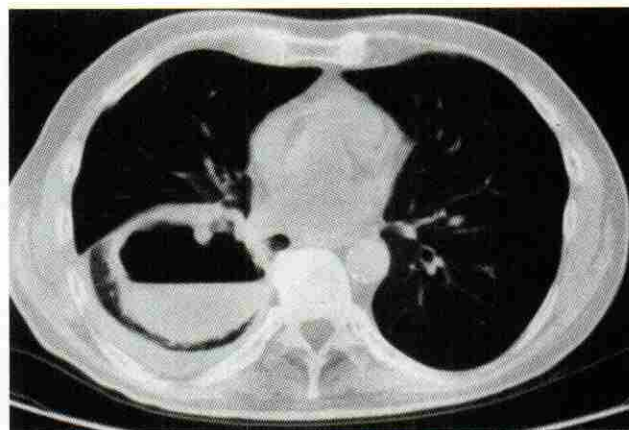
Computed tomogram of the chest shows a large cavitated squamous cell carcinoma. Note air-fluid level in mass and nodular irregular cavitary wall thickening consistent with malignancy; small right pleural effusion.
